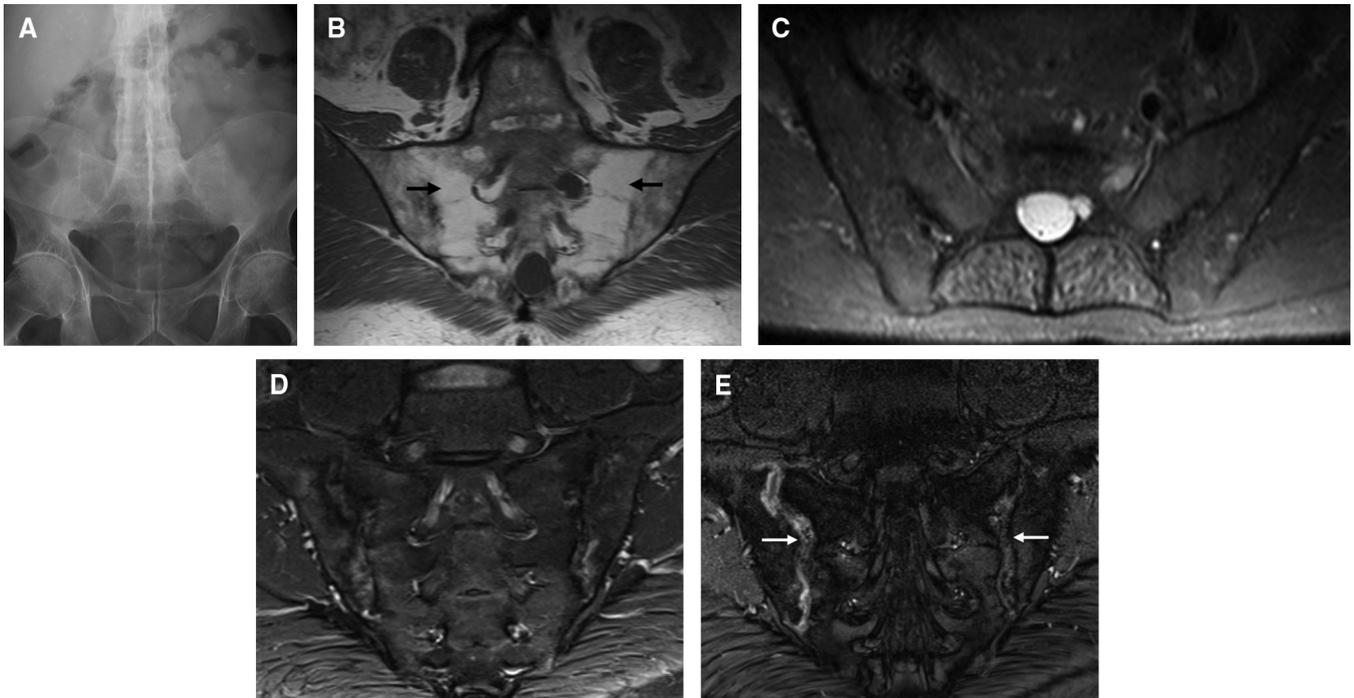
Inflammatory sacroiliitis. (A) Ankylosing spondylitis with diffuse syndesmophytic ankylosis of the spine and sacroiliac joint fusion. (B) Corresponding coronal T1-weighted magnetic resonance imaging demonstrates subchondral fatty replacement and bony fusion consistent (black arrows) with end stage ankylosis from previous sacroiliitis. (C) Axial short tau inversion recovery sequence confirms lack of bone marrow oedema to suggest acute disease activity. (D) Coronal short tau inversion recovery and (E) coronal T1-weighted fat saturated postcontrast sequences in a different patient with ankylosing spondylitis show symmetrical bilateral joint erosions, bone marrow oedema and joint enhancement (white arrows) consistent with active sacroiliitis. Bony ankylosis has not yet occurred in this patient, who would benefit from disease modifying therapy.
